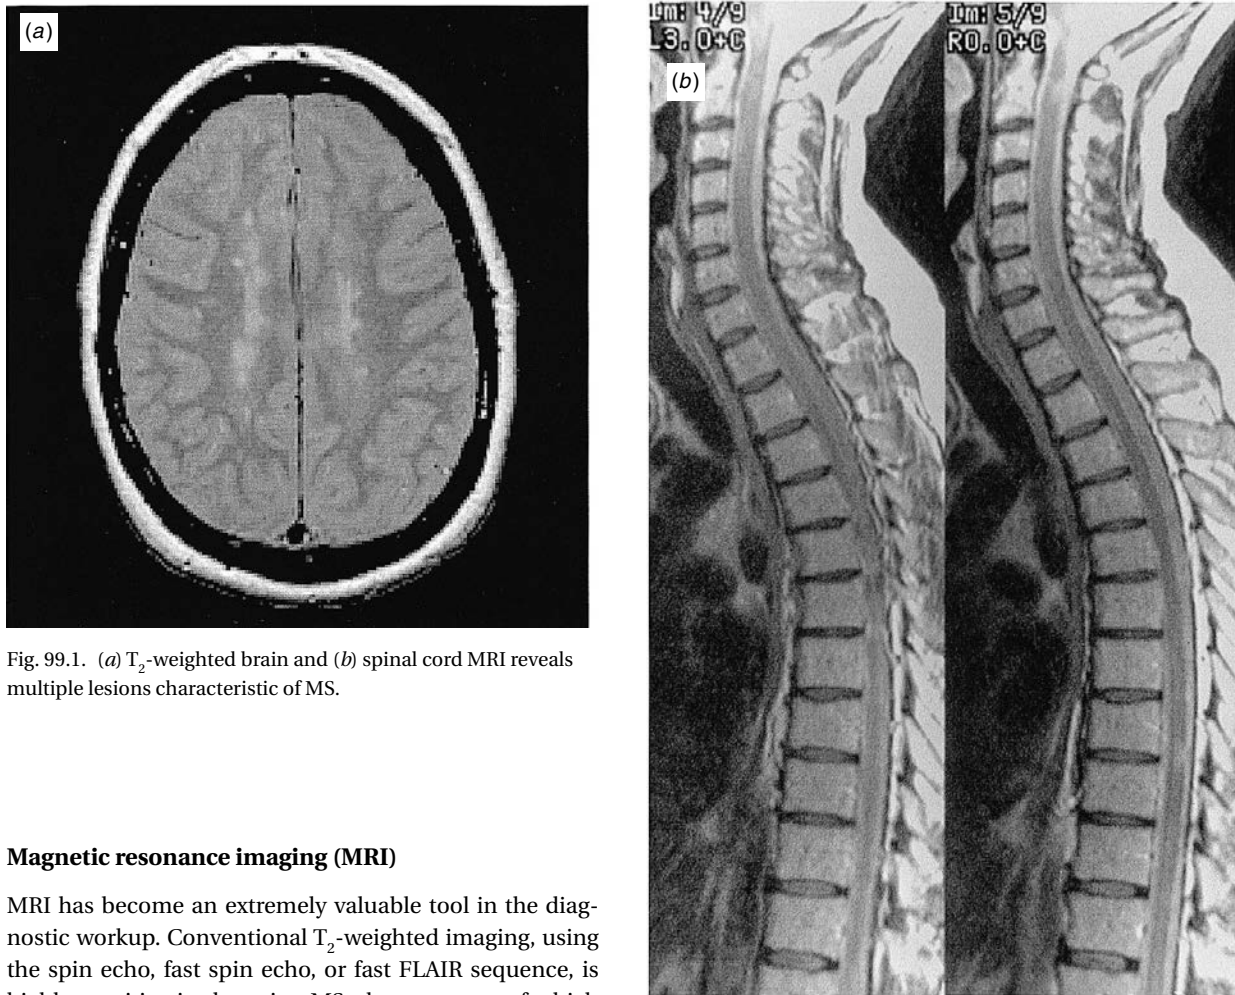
(a) T_2 -weighted brain and (b) spinal cord MRI reveals multiple lesions characteristic of MS.
